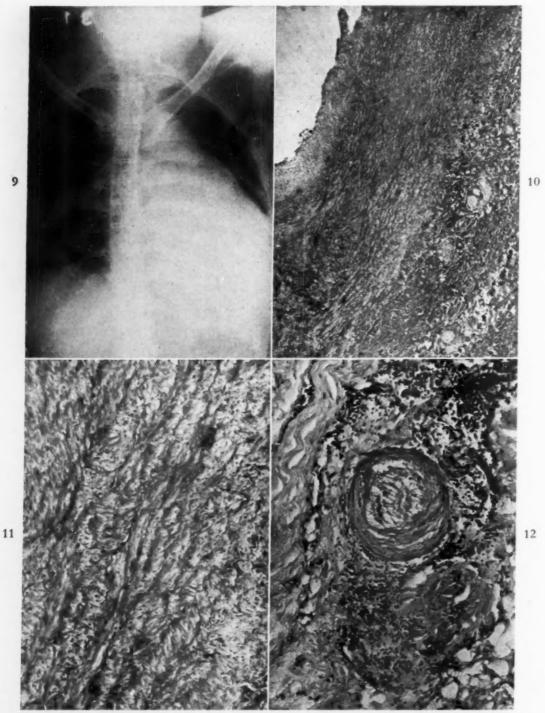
Case II. Roentgenogram of the chest. The heart is enlarged, and there is calcification of the spinal ligaments. Postmortem examination showed changes of rheumatoid spondylitis in the sacroiliac joints.
